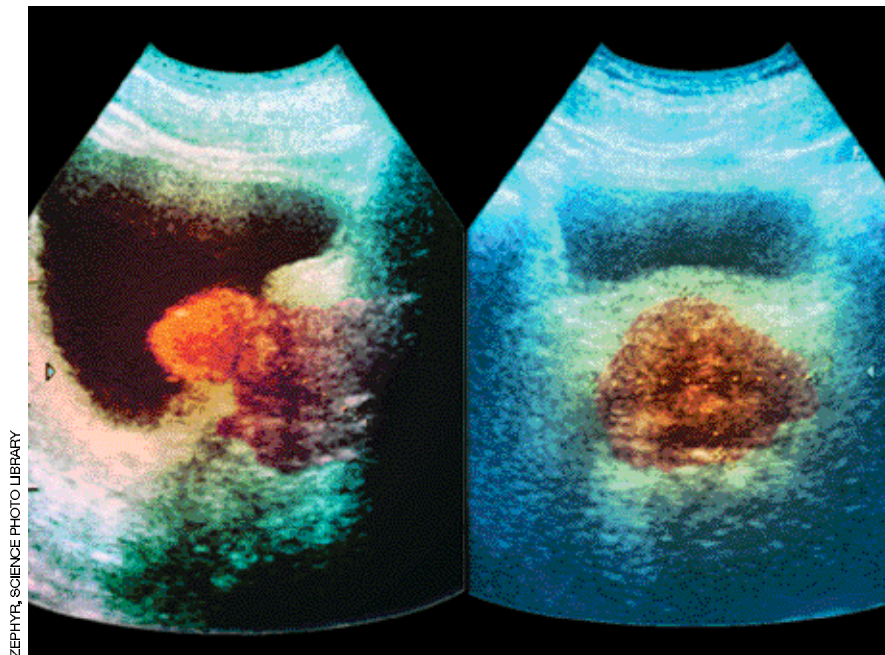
Pelvic ultrasound showing enlarged prostate and small postvoid residual.
